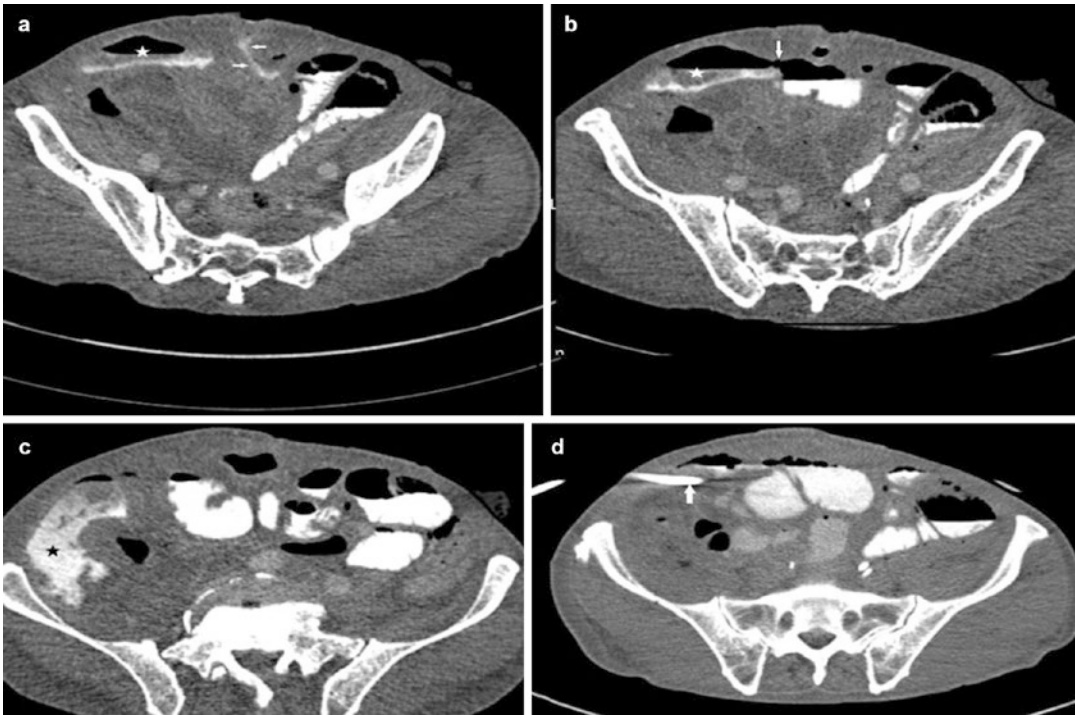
CT images of enterocutaneous fistula (arrows in a), bowel perforation (arrow in b) and intra-abdominal collection (*) during surveillance due to severe small
